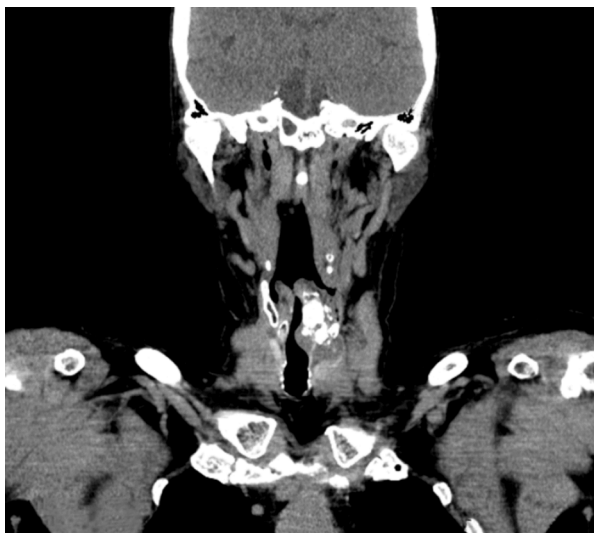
Computed tomography of laryngeal chondrosarcoma.
